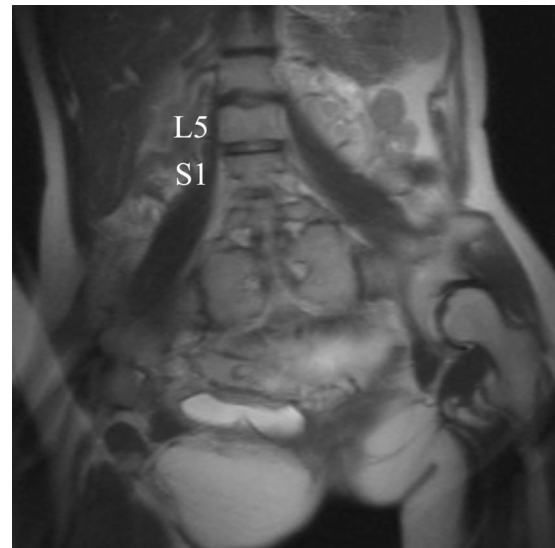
T2-weighted coronal magnetic resonance image of lumbar spine. Note the open sacral hiatus and partial sacral agenesis.
